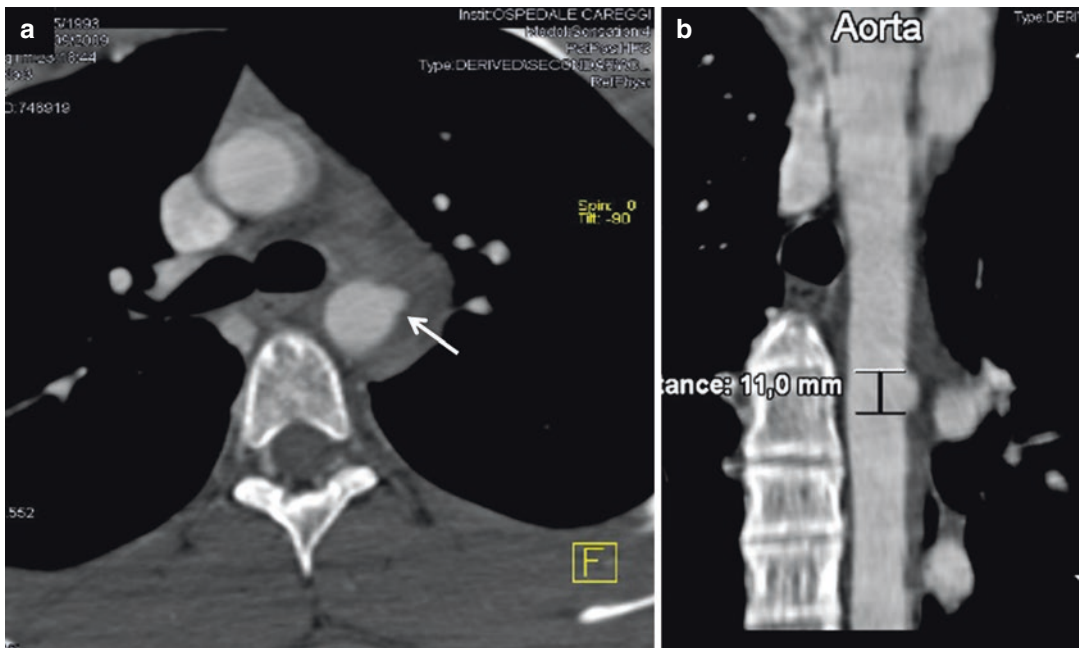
Isthmus, small pseudoaneurysm with periaortic hematoma. (a) Axial CT scan (white arrow); (b) reformat linear 2D image (size 11 mm)
